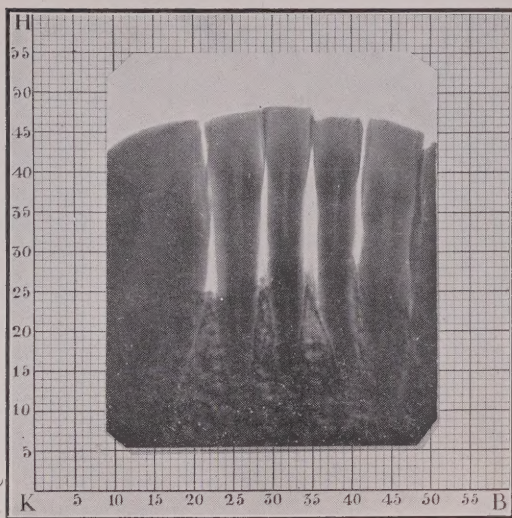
Regeneration of Alveolar Bone. Radiograph taken Mar. 1, 1922, at approximately the same angle as the preceding radiograph. Note the height of the restored alveolar crest as compared with the height of the alveolar crests between the adjoining teeth. Note formation of an apparently normal lamina dura.
